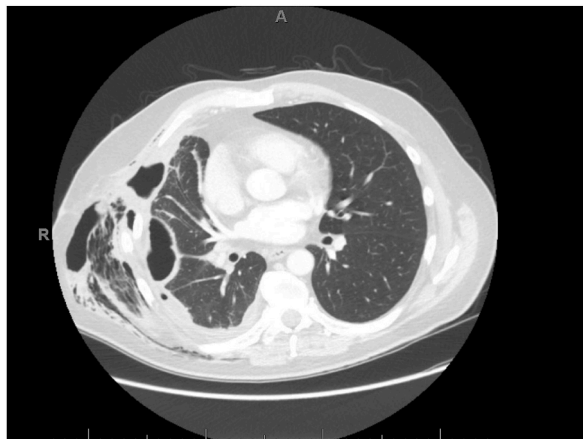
Post-operative CT chest demonstrating large right empyema with pleurocutaneous fistula along prior chest tube tract with extensive subcutaneous emphysema.
